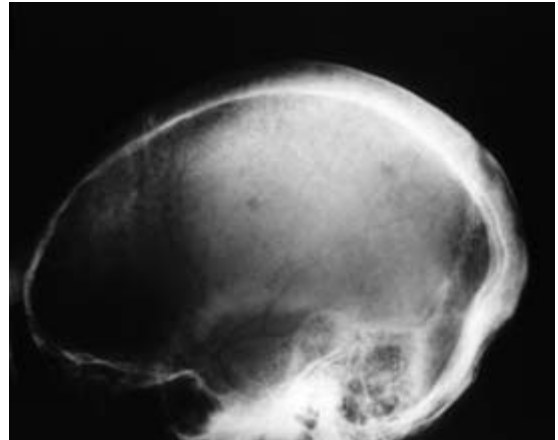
Skull radiograph in sickle cell anaemia showing expansion of the bony cavity resulting from hyperplastic erythropoiesis.
